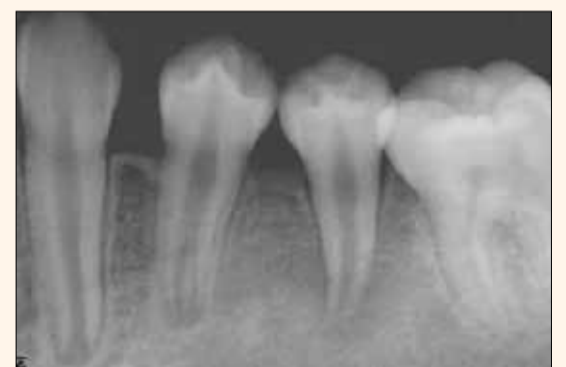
Radiograph of a necrotic lower left second premolar with large periradicular radiolucency with an incompletely formed root, both longitudinally and laterally.
